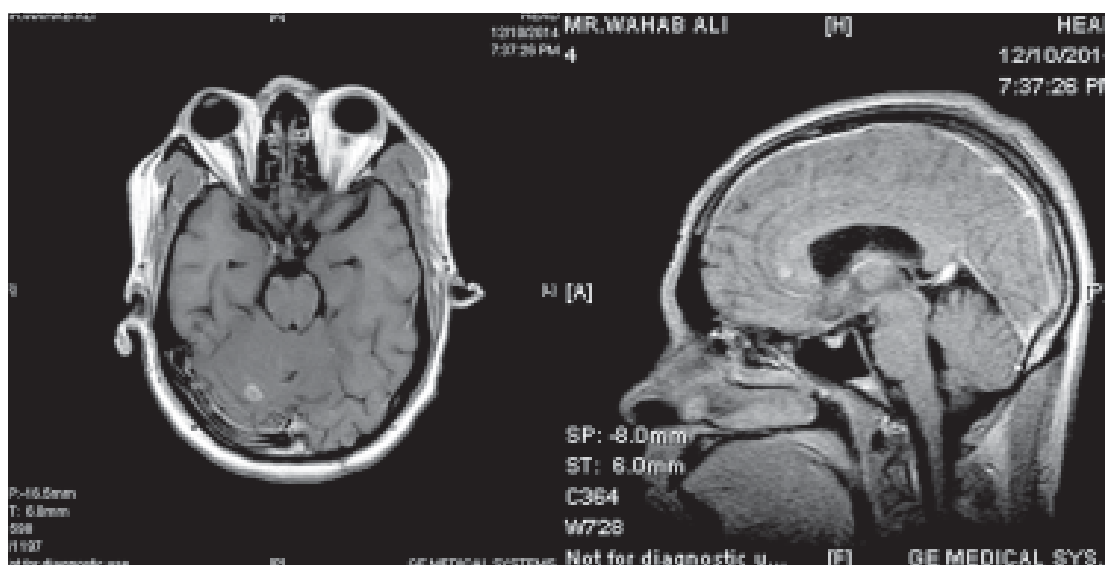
MRI of brain showing multiple, hyper-intense ring-enhancing lesions at right cerebellar hemisphere and genu of corpus callosum.
